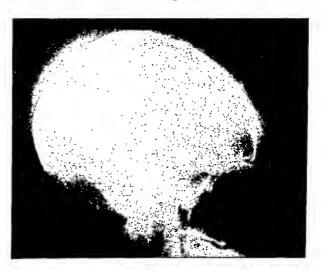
Case viii. Roentgenogram of skull showing area of metastasis. This region has been overexposed to show the bony spicules and soft tissue detail.
